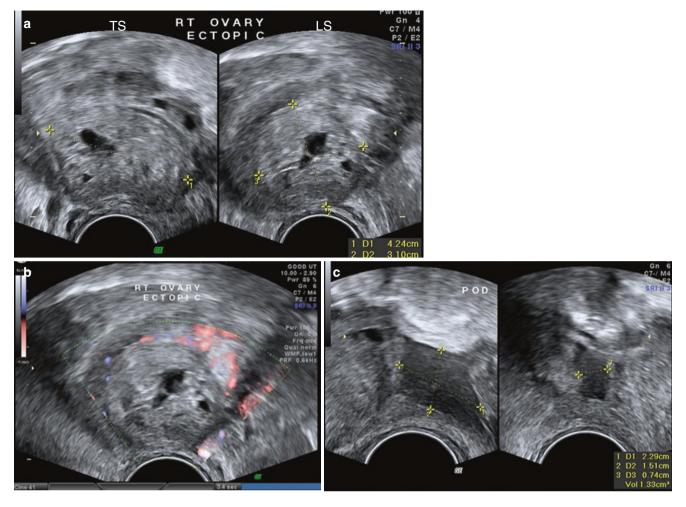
A case of ovarian ectopic pregnancy. Patient had a laparoscopy done for a right tubal ectopic pregnancy. The tube was found to be normal and was apparently 'cleaned up'. In view of rising beta hCG and discomfort experienced by the patient, a scan was repeated, which revealed an ovarian ectopic pregnancy. (a) Thick trophoblastic tissue surrounding a central cystic space suggestive of a GS. (b) Flow was seen around the trophoblastic tissue on HD Doppler. (c) Turbid fluid suggestive of blood was seen in the POD, suggesting haemorrhage from the ectopic pregnancy. Beta hCG at the time of the scan was 4713 mIU/mL
